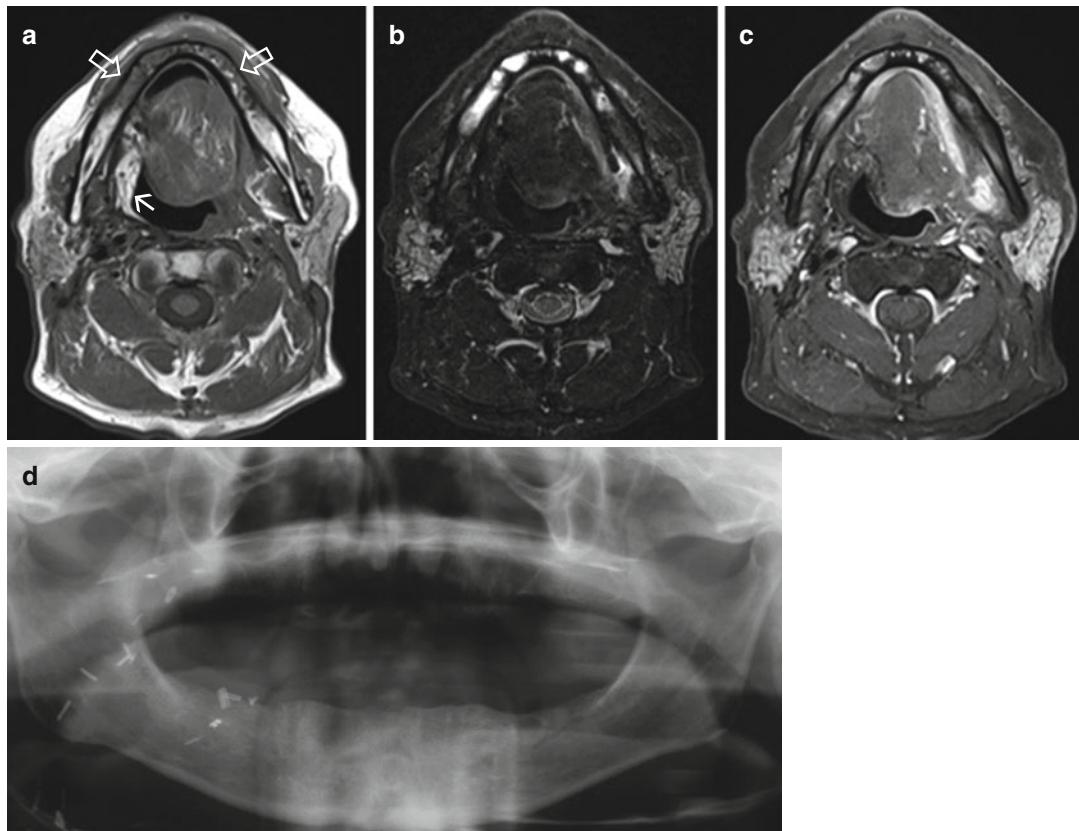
Osteoradionecrosis of the mandible after radiotherapy. MRI in a 62-year-old man treated with surgery and adjuvant RCTx for oropharyngeal cancer. Note free flap (white arrow) covering the resection defect in the right lateral oropharyngeal wall. Loss of fat signal
